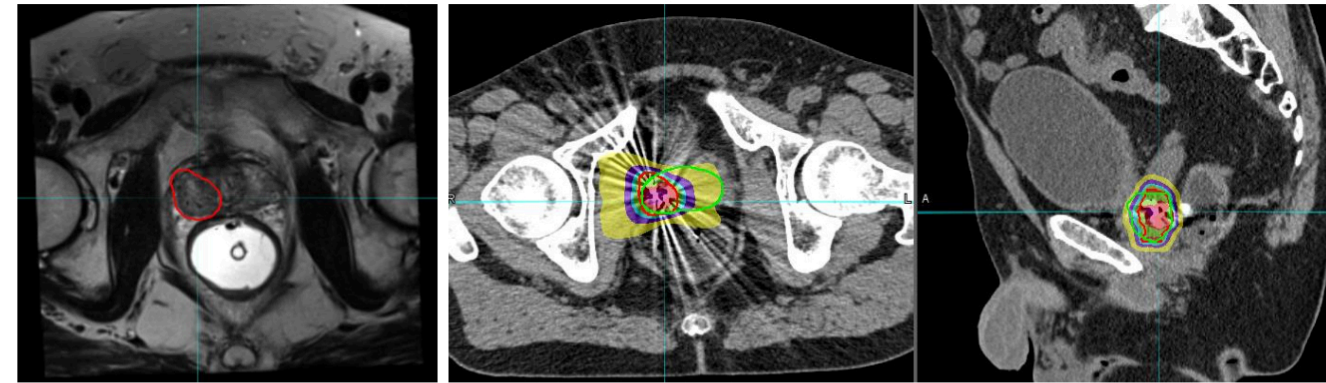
Image on the left is an MRI demonstrating a partial cancerous prostate and the image on the right is the resulting f-SBRT plan to the lesion in the prostate. The red contour is the PTV and the green contour is the whole prostate.
